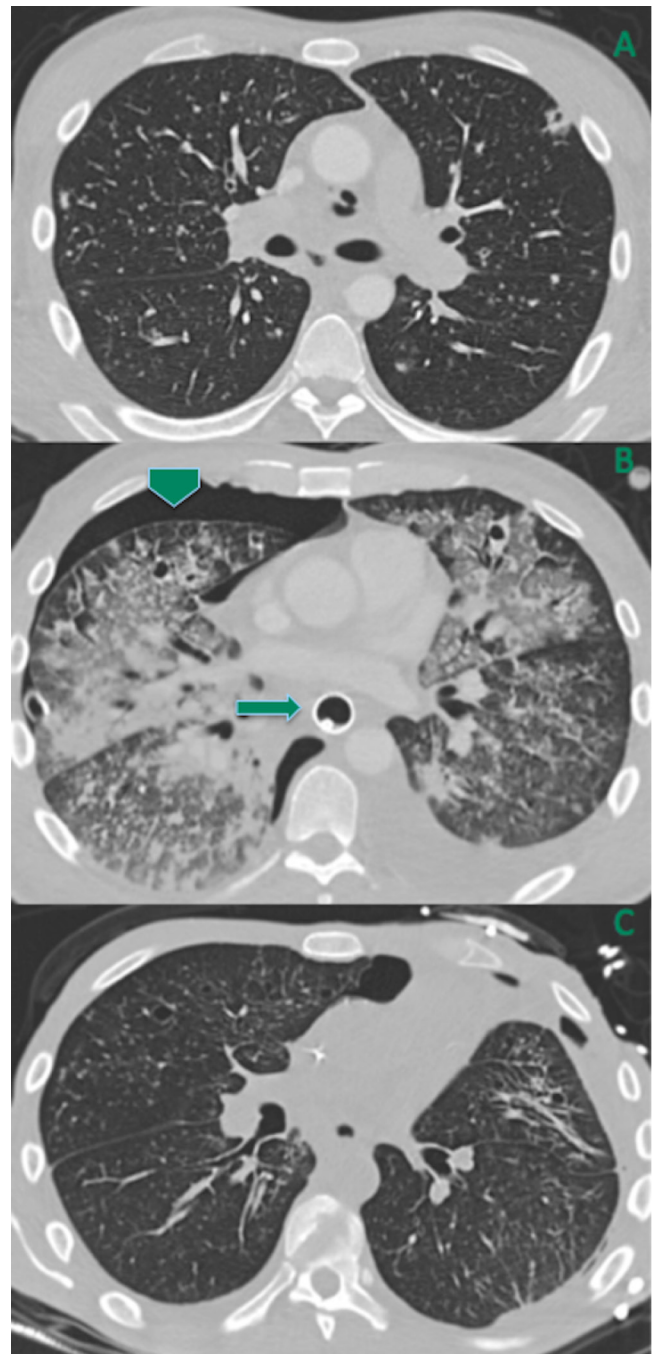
Sequential chest CT studies. (A) Multiple cavitary and non-cavitary lung nodules (same as Figure 3). (B) Hospital day 6: increased pulmonary tree-in-bud nodules and consolidations, new small right-sided pneumothorax (arrowhead), and new esophageal stent (arrow). (C) One month follow-up: nearly-resolved pulmonary opacities, decreased tiny right pneumothorax, and removal of esophageal stent.
